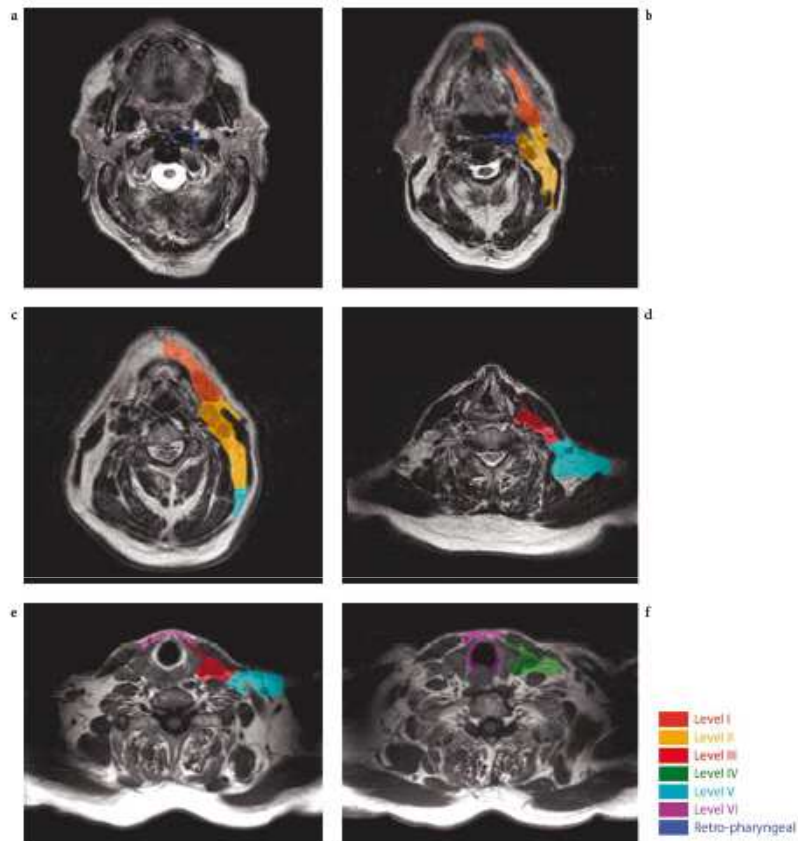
MRI of the same patient with a T1N0M0 glottic SCC (see tumor in *panel d*). The examination was performed on a Gyroscan NT 1.5 T Philips Medical Systems (Eindhoven, the Netherlands) on an axial plane with a slice thickness of 4 mm, a gap of 2 mm, and a field of view of 240 mm. T2-weighted images (TR 7976 ms and TE 90 ms) are displayed in *panels a-d*. *Panels e and f* represent T1-weighted images (TR 598 and TE 12 ms). Sections were taken at the level of the bottom edge of C1 (*panel a*), the upper edge of C3 (*panel b*), mid C4 (*panel c*), the bottom edge of C6 (*panel d*), the bottom edge of C7 (*panel e*), and mid D1 (*panel f*). Neck node levels were drawn on each slice using the radiological boundaries detailed in Table 3.11. The slight difference in the shape of the various levels between Figs. 3.2 and 3.3 is explained by a difference in the positioning of the patient, leading to a slight difference in slice levels. Each node level corresponds to the CTV, and thus does not include a security margin for organ motion or set-up inaccuracy
